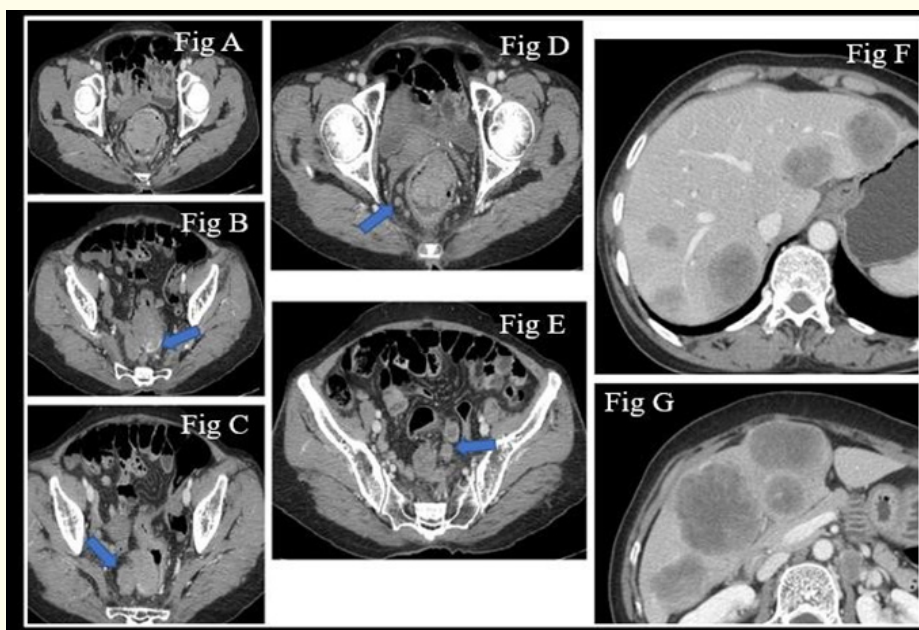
CT images of HPE proven Adenocarcinoma – Moderately differentiated. A: Axial venous phase shows and endophytic heterogeneously enhancing lesion in the rectum. B: Arterial phase showing vascular pedicle in the posterior aspect. C: Exophytic component of the lesion. D and E: Multiple conglomerated lymph nodes. F and G: Liver metastases.
